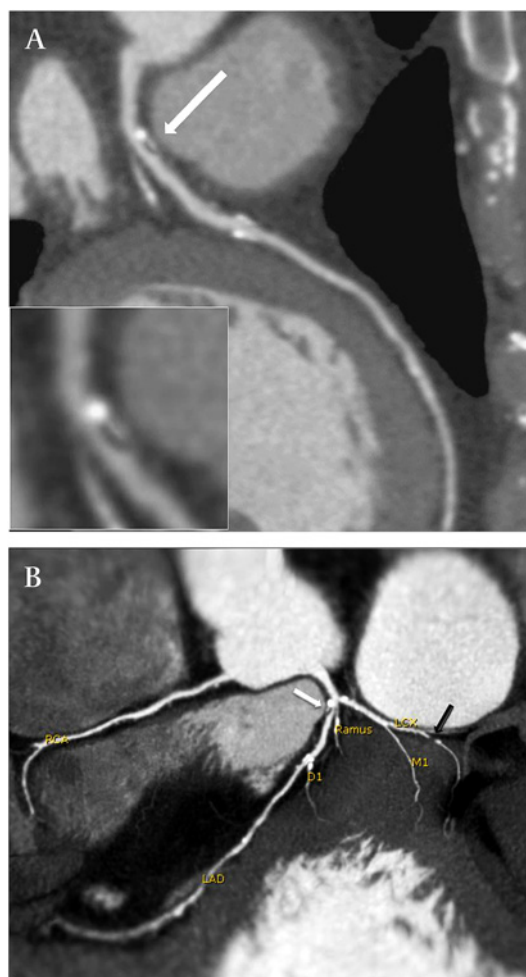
Coronary CT angiography at admittance. (A) Multiplanar reconstruction of the left anterior descending (LAD). In the proximal part of the vessel, a moderate partially calcified stenosis is present. The distal part of the lesion has a low attenuation profile and intradye penetration which suggests ulcerated plaque (white arrow). (B) 2D reconstruction. The black arrow shows a severe non-calcified lesion in the left circumflex artery (LCX) without any signs of instability.
